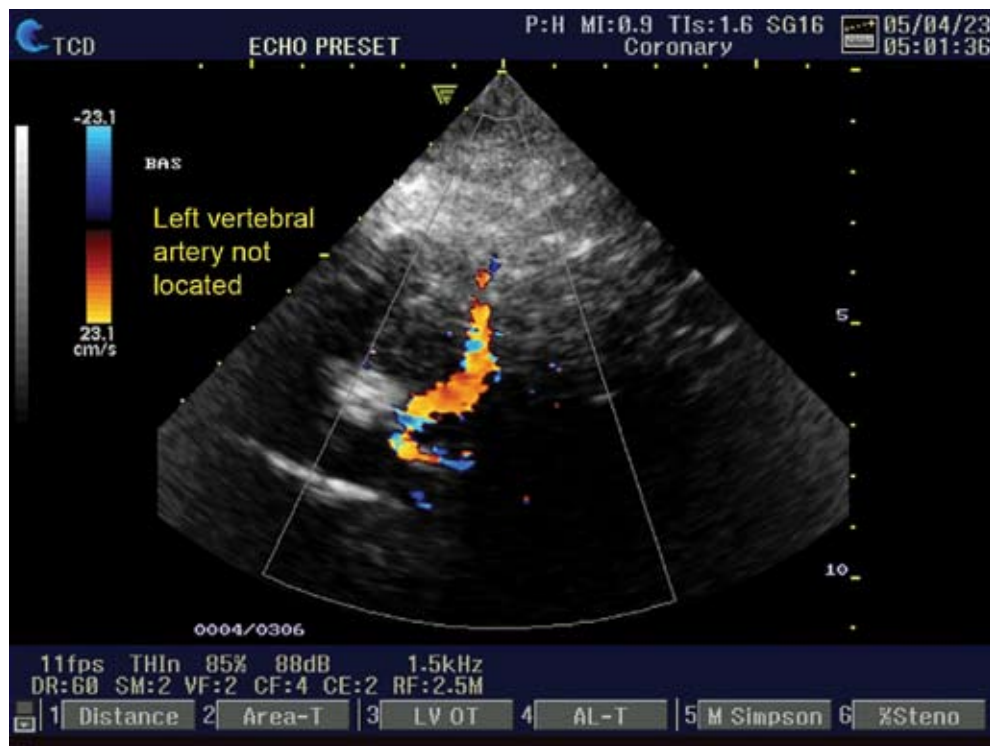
Color Doppler ultrasound of right vertebral artery showing large caliber with normally directed flow.
